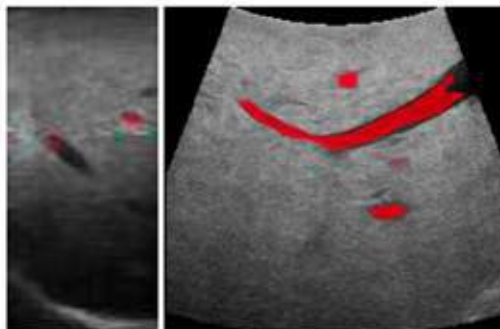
US images and results of automatic vessel segmentation of liver from integrated (left) and BK Flex 800 ultrasound system.
